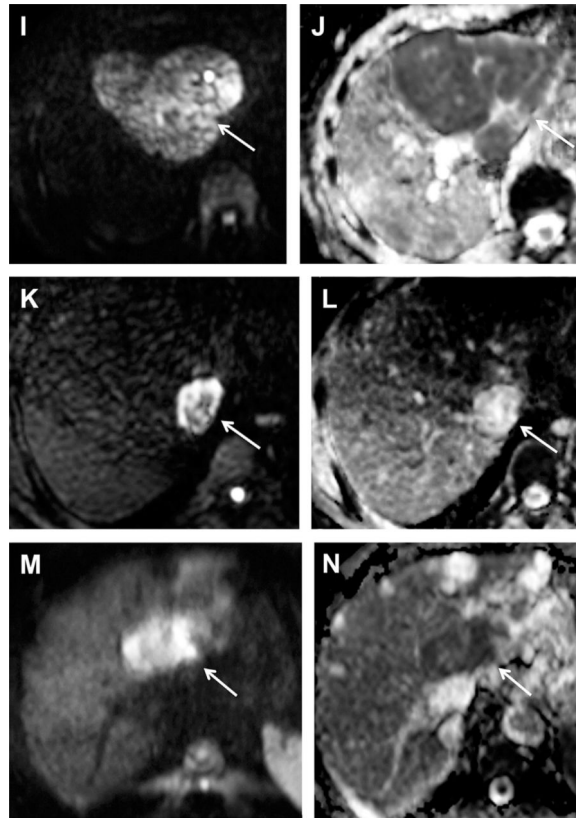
Typical behavior on DWI of the most common focal liver lesions (*arrows*). Paired high b-value image and corresponding ADC map of (A, B) Simplecyst: ADC value: $2.1 \times 10^{-3} \text{mm}^2/\text{s}$. (C, D) Hemangioma: ADC value: $1.4 \times 10^{-3} \text{mm}^2/\text{s}$. (E, F) FNH ADC value: $1.5 \times 10^{-3} \text{mm}^2/\text{s}$. (G, H) Hepatocellular adenoma: ADC value: $0.9 \times 10^{-3} \text{mm}^2/\text{s}$. (I, J) HCC: ADC value: $0.65 \times 10^{-3} \text{mm}^2/\text{s}$. (K, L) Colorectal liver metastasis: ADC value: $0.8 \times 10^{-3} \text{mm}^2/\text{s}$. (M, N) CHC: ADC value: $0.9 \times 10^{-3} \text{mm}^2/\text{s}$. Notice the overlap in ADC values between benign and malignant solid lesions.
